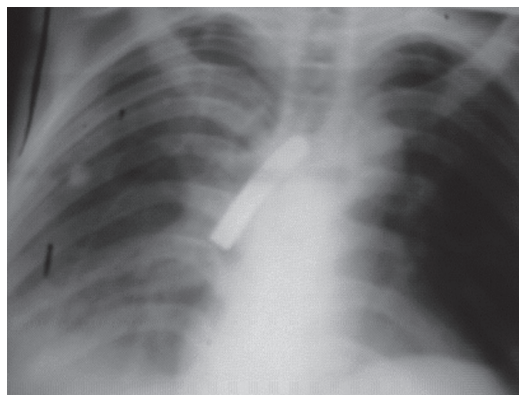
A portable chest x-ray revealing a segment of the metallic tracheostomy tube in the right main bronchus stem.
